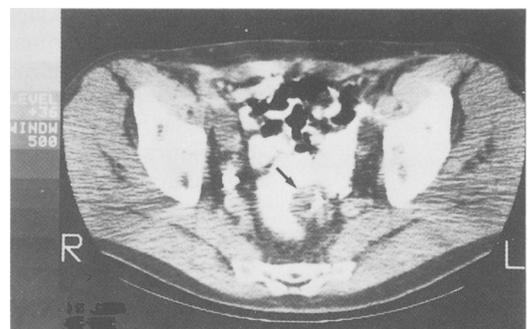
Computed tomography of pelvis showing same defect on left lateral wall of pouch.
